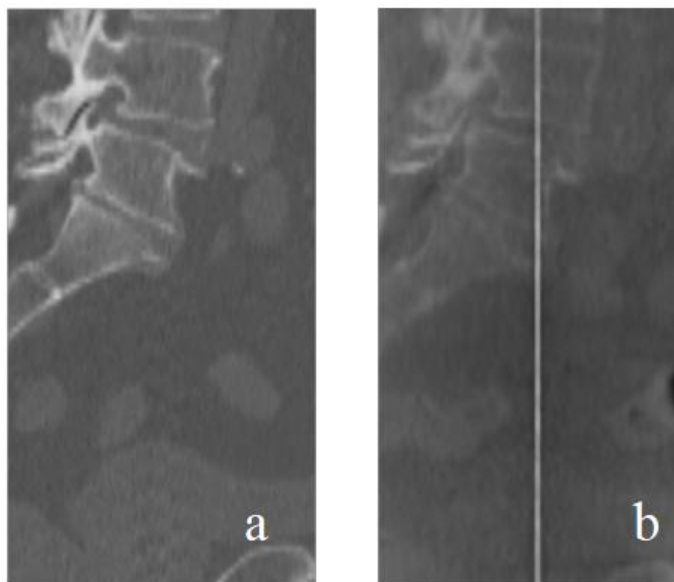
Line artefact. In the reconstructed CBCT (b) appears a line artefact that is not present in planning CT (a) and that propagates in SART method.
